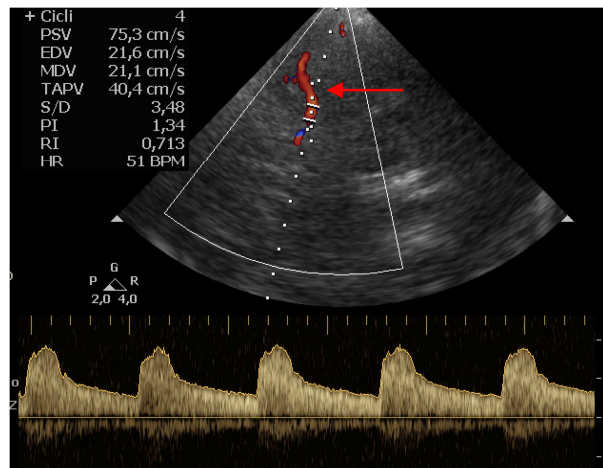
Transcranial Color Doppler (Arrow: middle cerebral artery).
